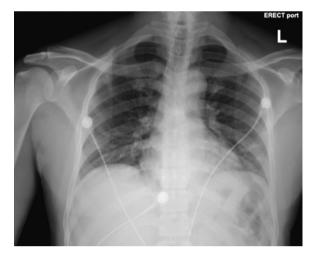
Admission chest radiograph without acute changes.
